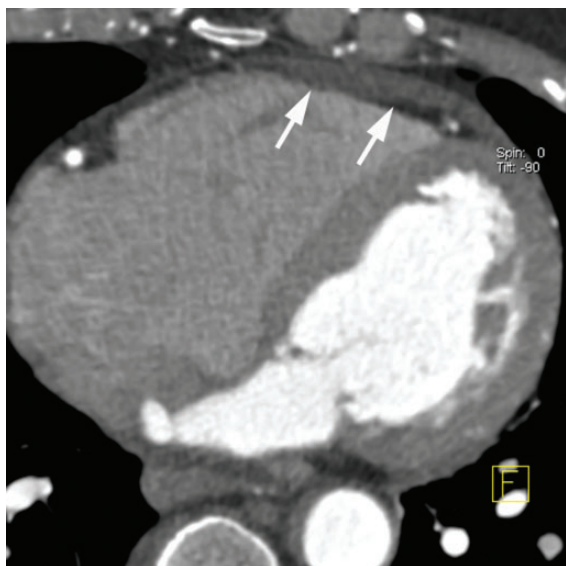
Small accumulations of fluid can mimic pericardial thickening in CT, since the CT attenuation of fluid and pericardial tissue can overlap. Here, some pericardial fluid creates the impression of thickened pericardium anterior to the right ventricle (arrows).
